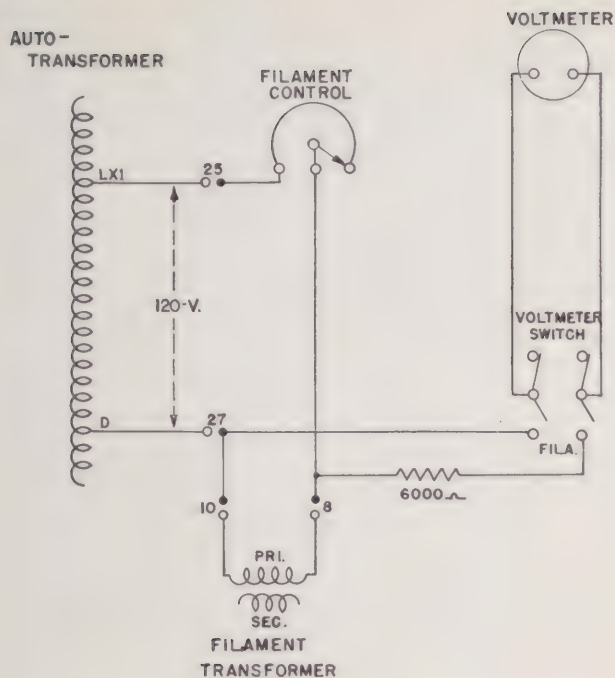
X-ray filament circuit—Item No. 96215.
